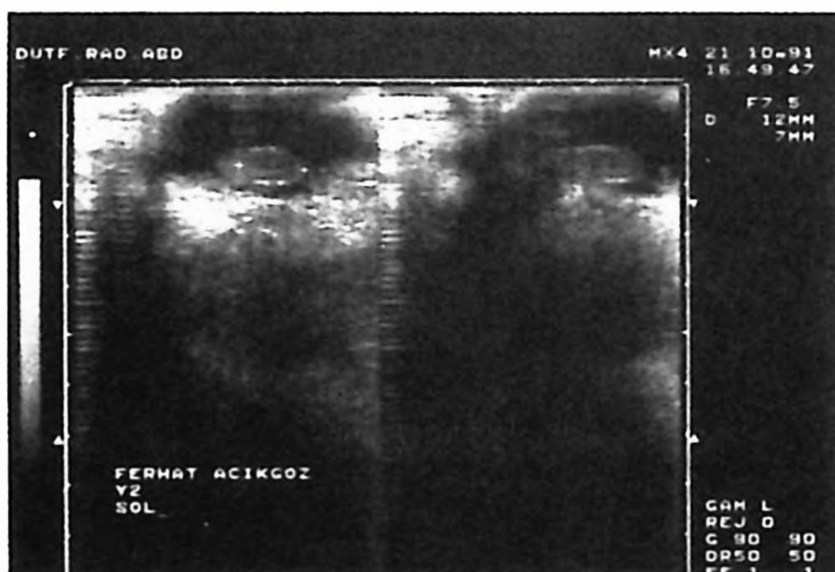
Ultrasonographic appearance of the testis.
